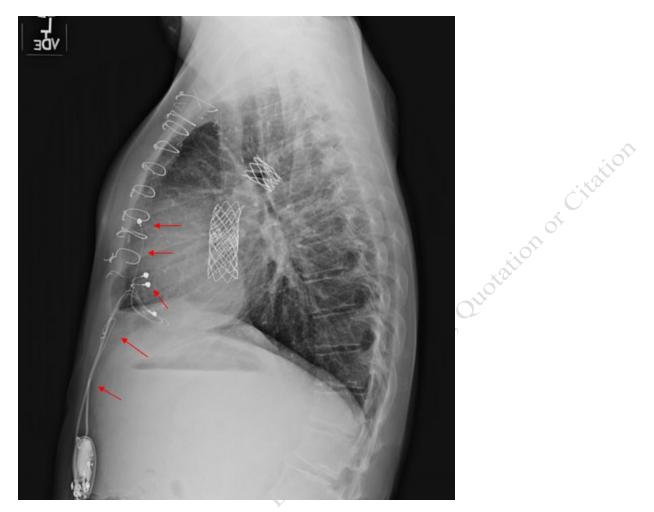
Lateral chest radiograph demonstrating relatively long permanently implanted epicardial leads (and attached to a pulse generator). There are presently insufficient data to comment on the safety of performing MRI with this class of leads.
